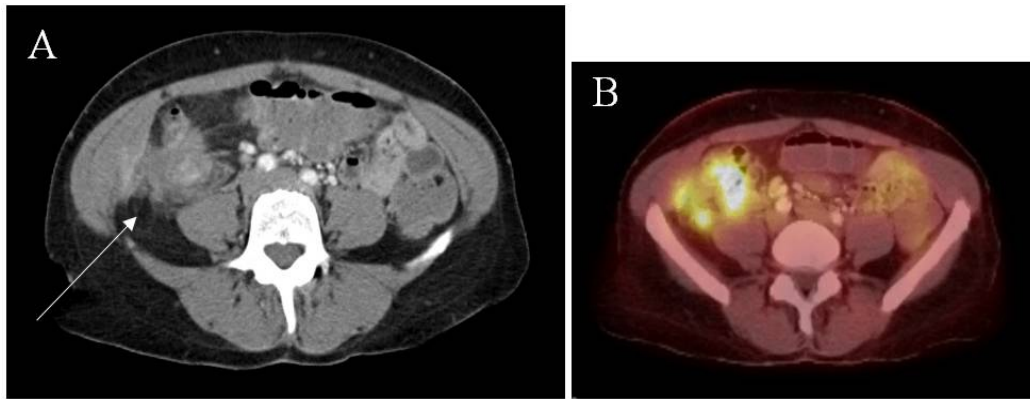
Imaging obtained approximately 15 months after index operation to remove cystic mass. (A) Computed tomography of the abdomen and pelvis demonstrated a new intraabdominal mass near the location of her previously resected adenocarcinoma. (B) Positron emission tomography confirmed a heterogeneously enhancing density within the right abdomen, concerning for recurrence of her malignancy.
